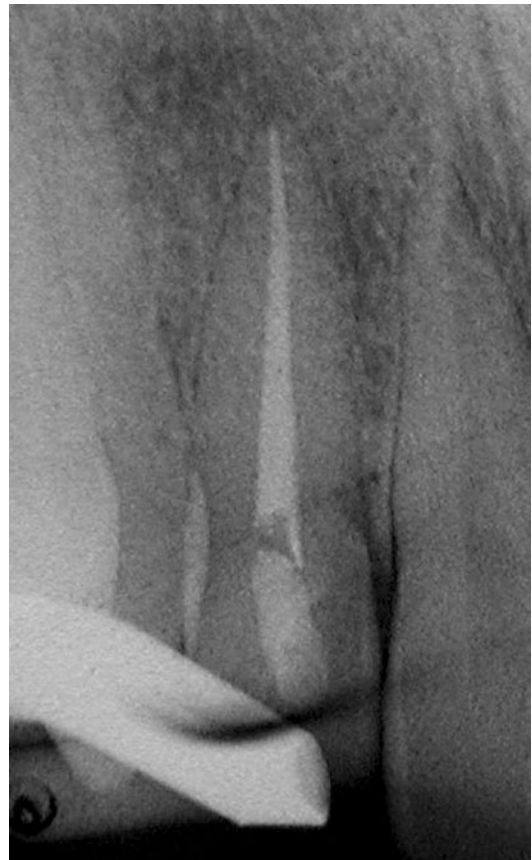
Periapical image of tooth #7 with an endodontic procedure. Note that no periapical or coronal disease processes are evident
